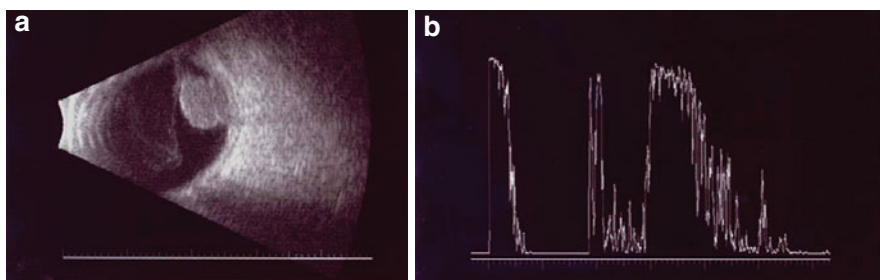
Ultrasonography demonstrates the features of a mass consistent with left-sided cilio-choroidal melanoma. (a) The first scan is a B-scan sonogram with a collar-button appearance. (b) The second scan is an A-scan sonogram with low internal reflectivity
